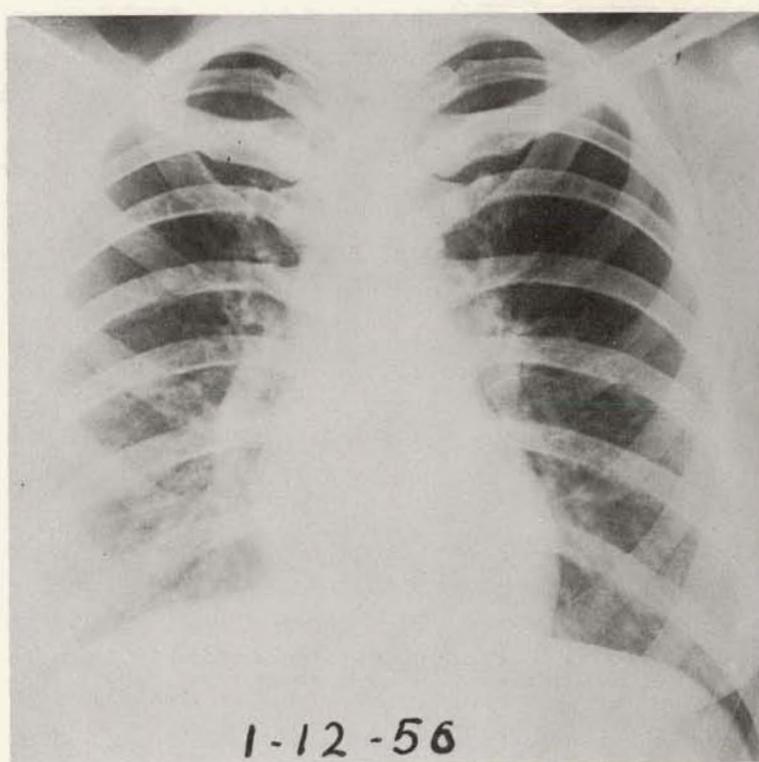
Same patient as shown in Figures 71 to 74. Roentgenograph of chest, January 12, 1956. She had been taking 3 grains of desiccated thyroid daily, since October 5, 1951.
